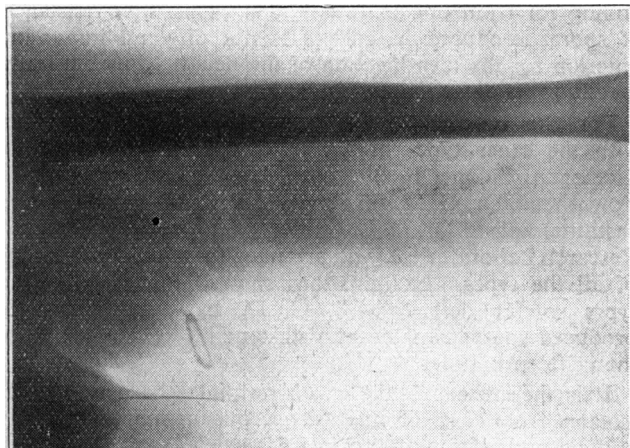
Radiograph of thigh showing gas in soft tissues
